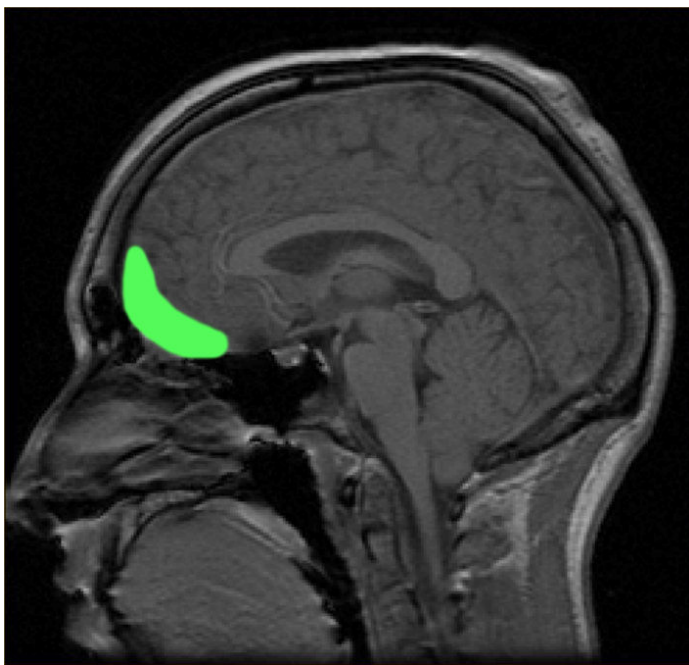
MRI image of a parasagittal section of the brain showing the orbitofrontal cortex (green).
